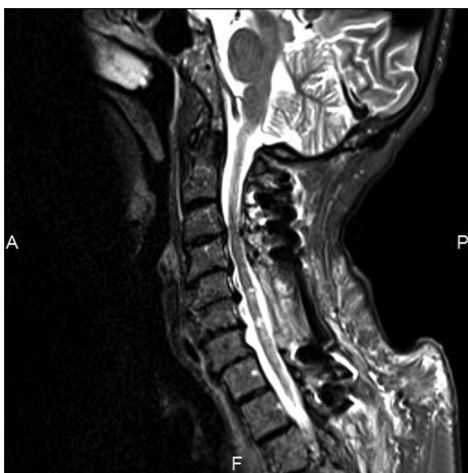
Postoperative T2-Weighted MRI Scan of Patient with Multiple Sclerosis Following a Cervical Laminectomy C5, C6, C7 Followed by C2-T2 Fusion. The study demonstrated chronic cord atrophy and marked focal intracord T2 hyperintensity from C4-C7, most prominent at/immediately below the C45 level. A central less intense signal was seen at C3 without cord expansion/pathological enhancement, consistent with the history of MS and chronic myelomalacia. Excellent decompression of the spinal canal was seen at all levels without recurrent/residual spinal stenosis/extrinsic cord deformity
